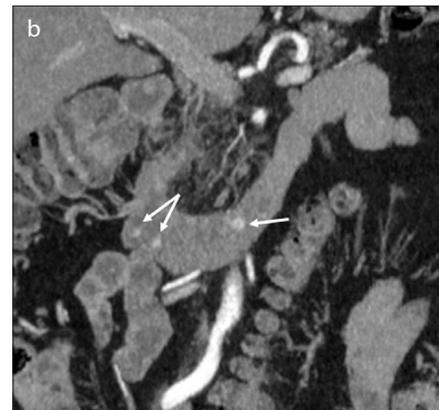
a, b. Multiple well-differentiated tiny enhancing duodenal carcinoid tumors (*arrows*) on axial (a) and coronal reconstructed (b) maximum-intensity CT images in a 56-year-old man with NF-1. An enlarged periduodenal lymph node is also seen (a, *short arrow*).
